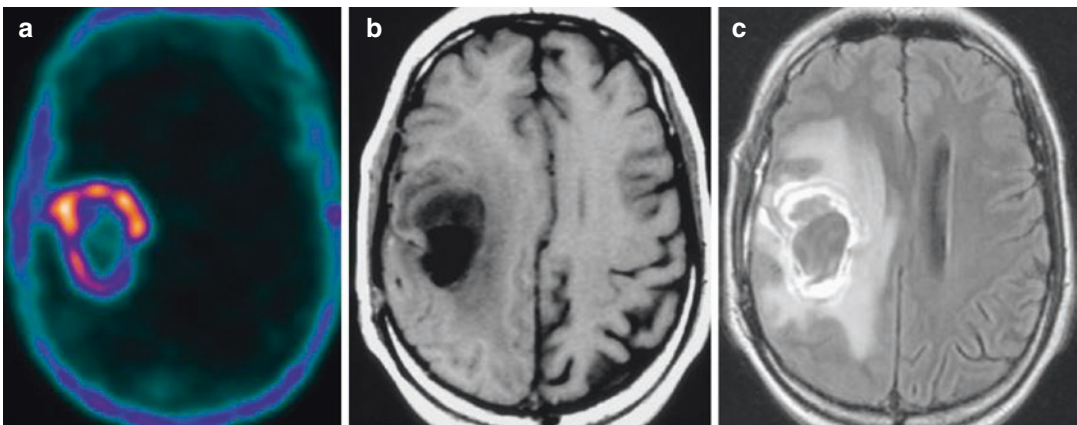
A 64-year-old patient undergone surgical excision of a right frontotemporal glioblastoma. One year after, the PET/MRI showed diffused ^{18}F -FMC uptake along the margins of the postsurgical hypointense lacunar area, as showed in axial PET (a) and T1-weighted MRI
